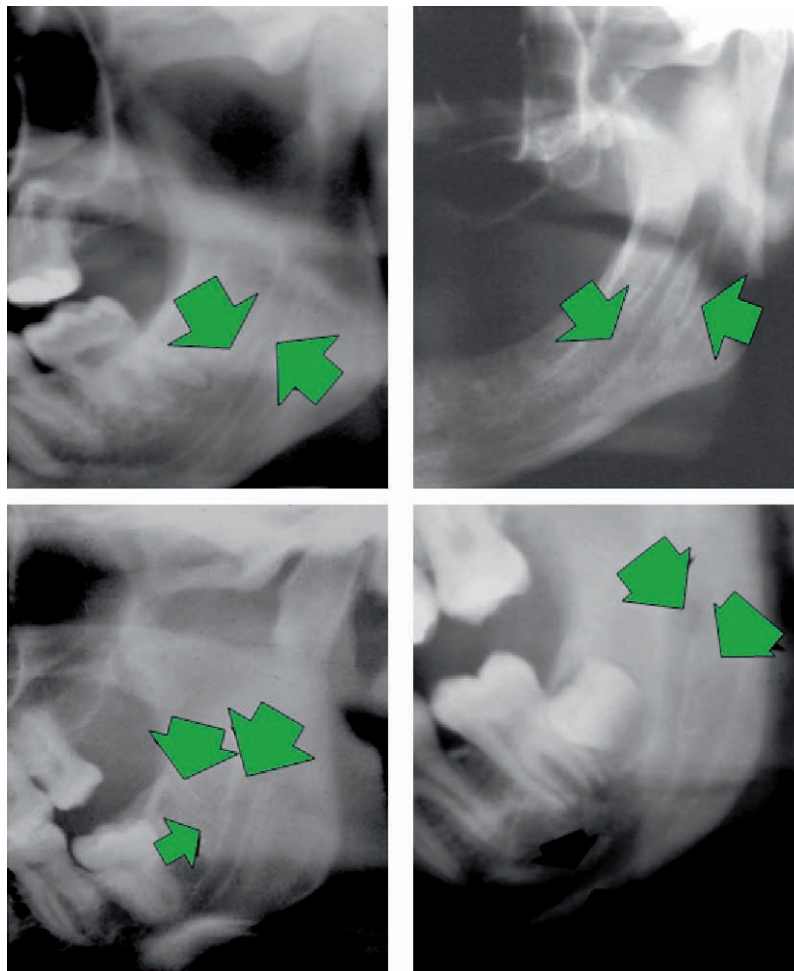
Details from panoramic radiographs demonstrating various duplicate, or bifid, mandibular canals
